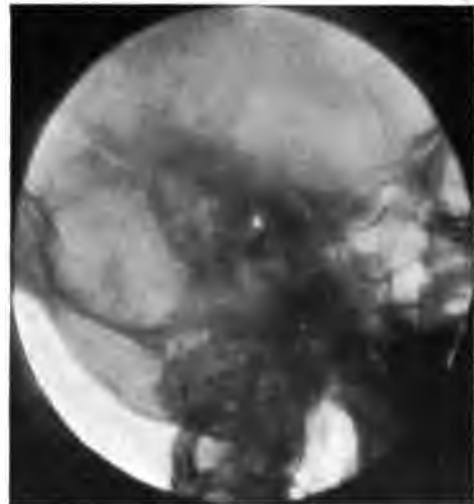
CASE 6025. FEMALE AGE 21. SAME TYPE AS ROENTGENOGRAM FIG. 10.
